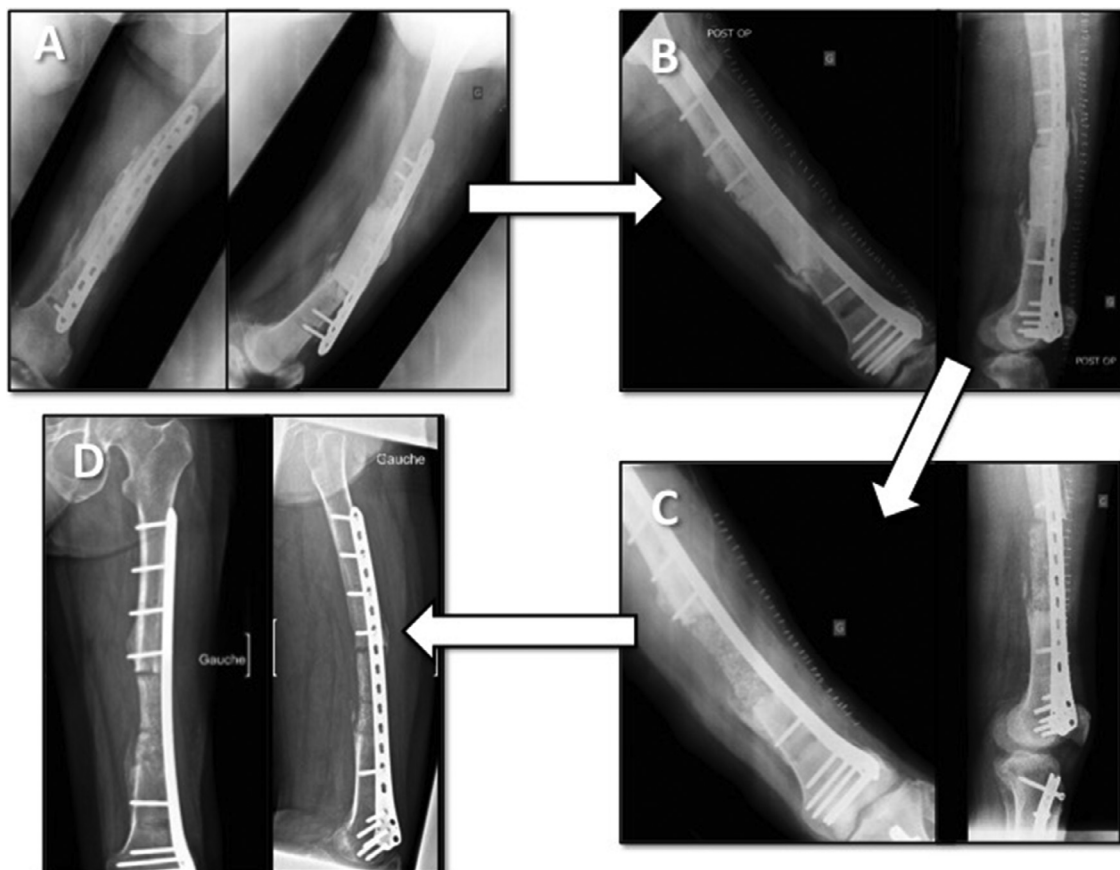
Example of a satisfying bone creation but a “docking side” like effect at the proximal part of a long graft in a left distal femur (A: pre-operative X-Rays, B: First stage X-Rays, C: Second stage X-Rays 4 months after the first one, D: X-Rays 6 months after grafting).
